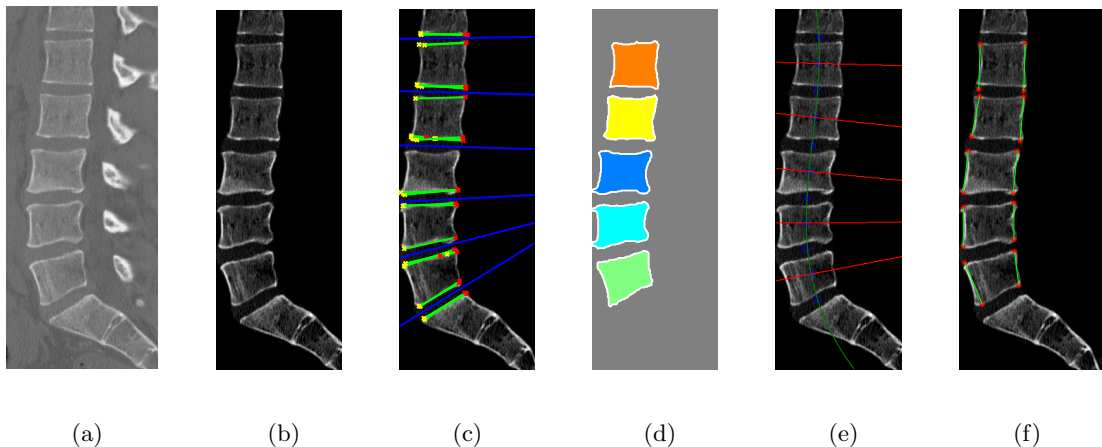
Fully automated processing steps for a case with no vertebral fracture : (a) shows the original CT scan, (b) shows the extracted ROI, (c) shows the Hough Lines in green and the vertebra separating lines in blue, (d) shows the segmented and labelled vertebrae, (e) shows the vertebral centerline in blue and orientation of each vertebra in red, (f) shows the automatically detected vertebral corners in red and the left and right vertebra height in green.
